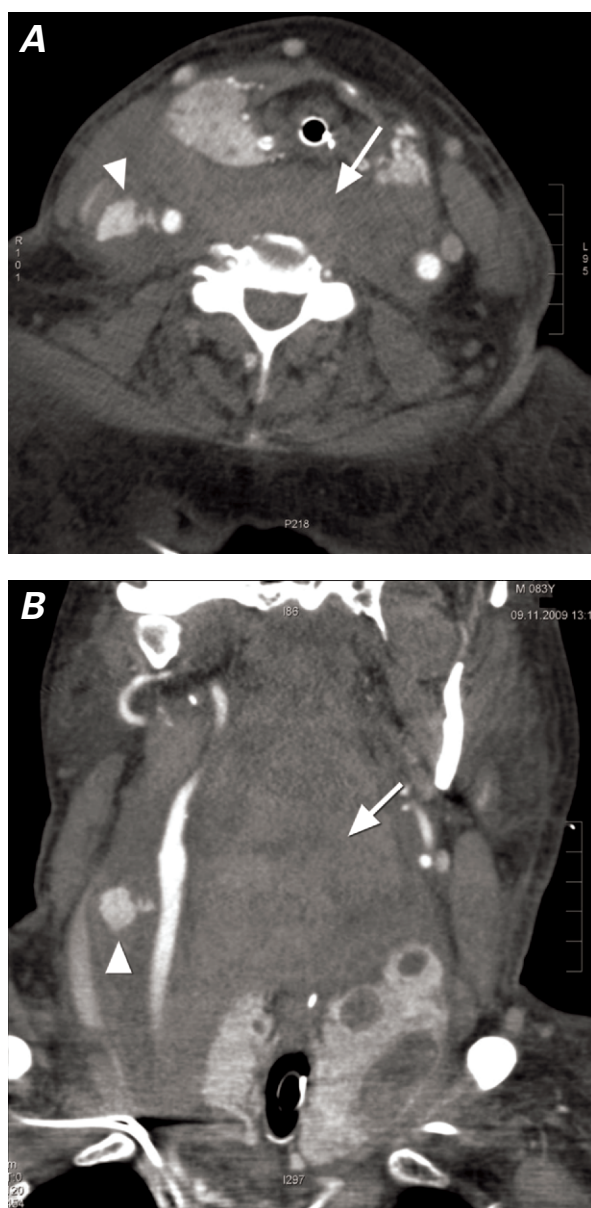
A) Axial and B) coronal computed tomographic images of the neck with contrast show the common carotid artery pseudoaneurysm (arrowhead) with a relatively long, narrow neck and large hematoma (arrow) in the surrounding soft-tissue planes.
